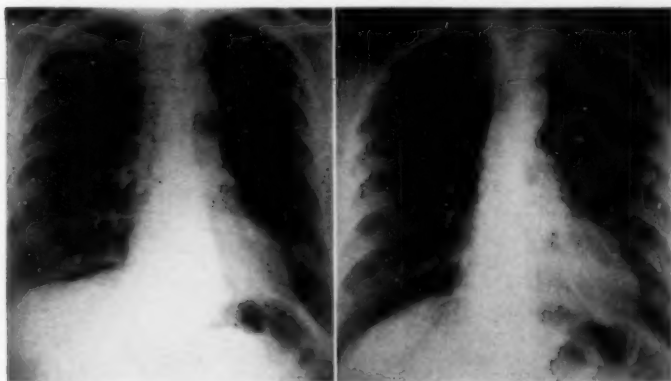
To left, roentgenogram showing atelectasis of the left lower lobe in a woman 34 years of age; note triangular shadow with superimposed heart shadow. To right, roentgenogram showing re-aeration of lower lobe after endoscopic treatment of tumor (B. A., Case 3).
